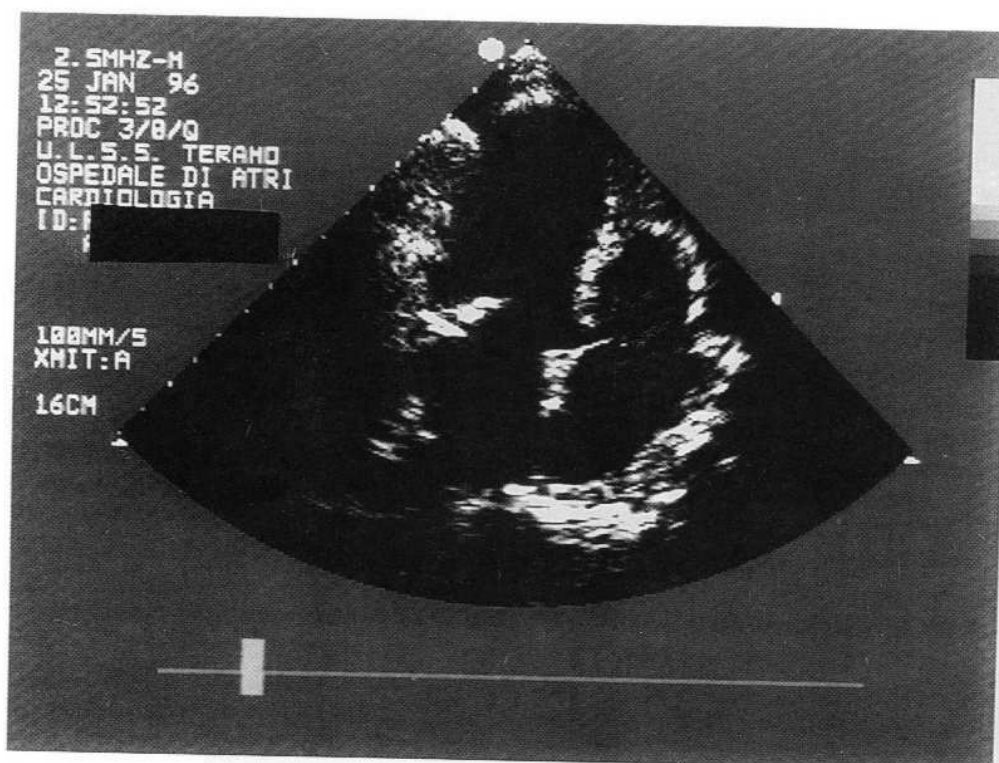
Echocardiography at day 46: a slight reduction of vegetations on valvular and subvalvular apparatus (mitral and semilunar valves) can be noted after correct therapy of the *Salmonella* infection.
